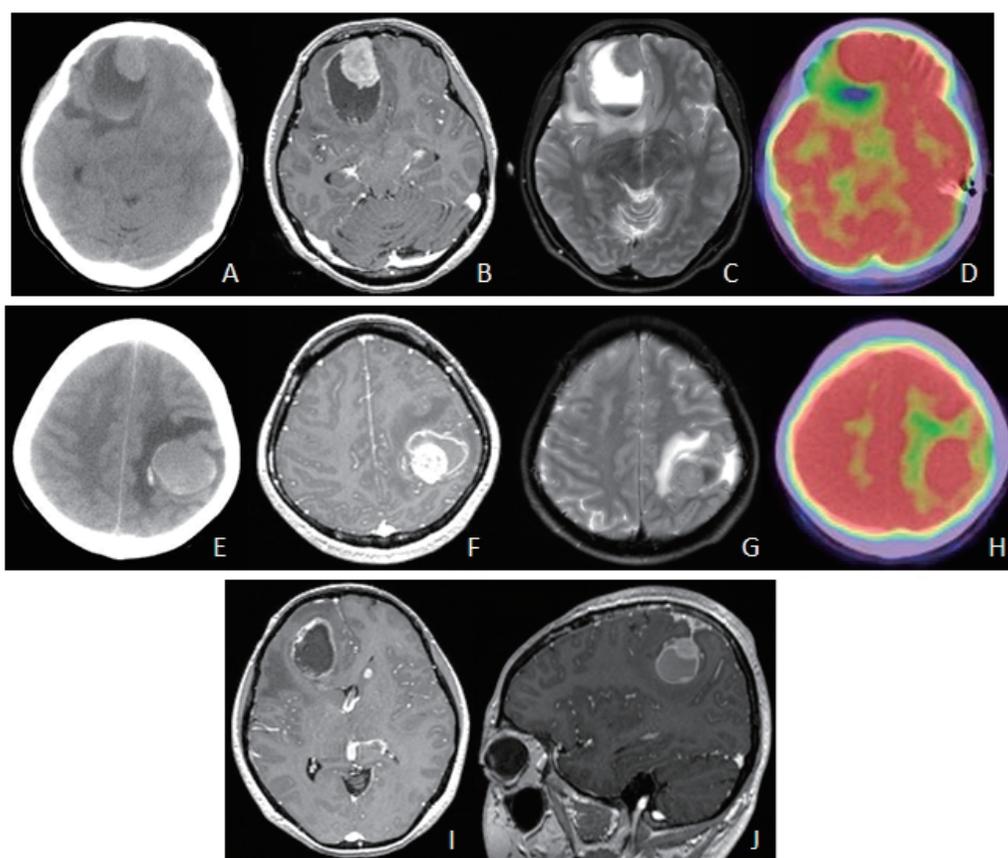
A, E: Computed tomography images reveal right frontal and left parietal mass lesions.
